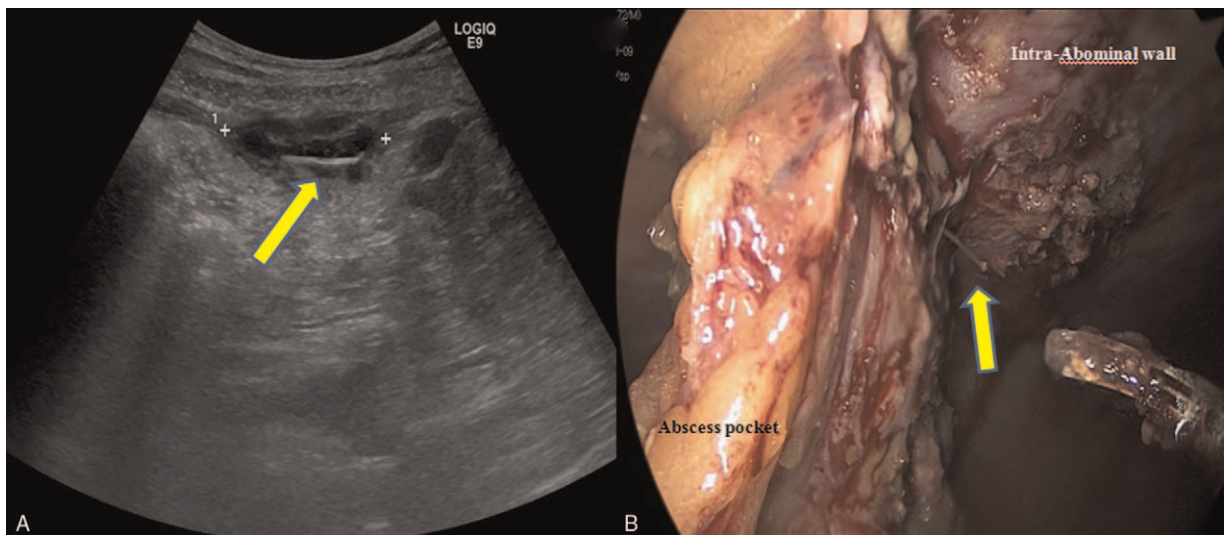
(A) Ultrasonography view of remained abscess formation with foreign body after 1 week with antibiotics therapy. (B) Intraoperative view of a 4 cm sized foreign body like toothpick appeared in the abscess pocket.
